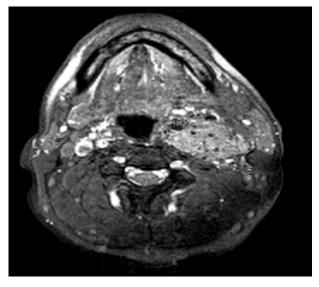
Axial T1-weighted MRI of neck post fat saturation reveals flow voids within the carotid mass.
